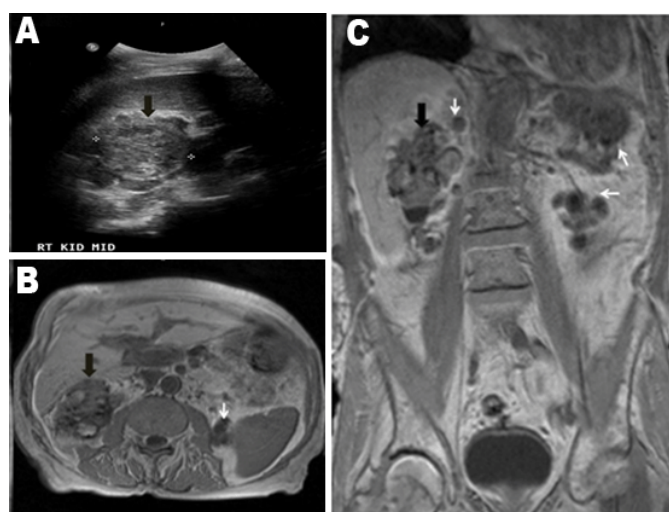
(A) Renal ultrasound showing the mass in the right kidney (arrow), (B, C) MRI abdomen showing heterogeneous mass suggestive of Renal cell carcinoma (black arrow) and bilateral native kidney cysts (arrows).
